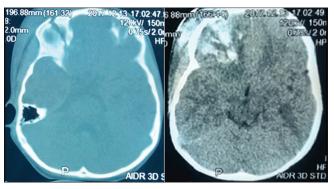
The first brain computed tomography scan shows fracture of the orbital roof and frontobasal hemorrhagic contusion.
